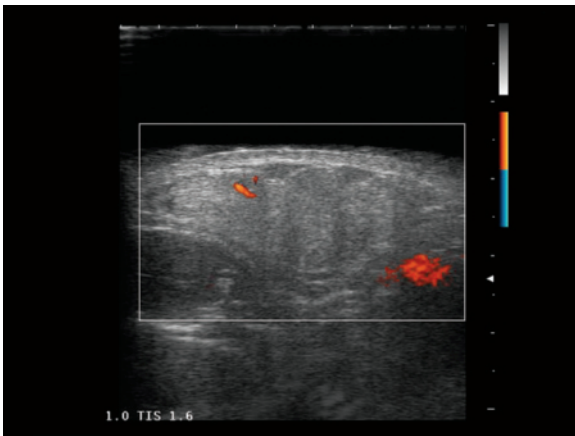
c Neurinoma of the vagus nerve. Spindle-shaped, well-defined, heterogeneous hypochoic nodulation (a). Multiple color signals, particularly centrally at directional PD (b). Coronal T2-weighted MR image visualizes heterogeneous hyperintense mass (c, arrows)
